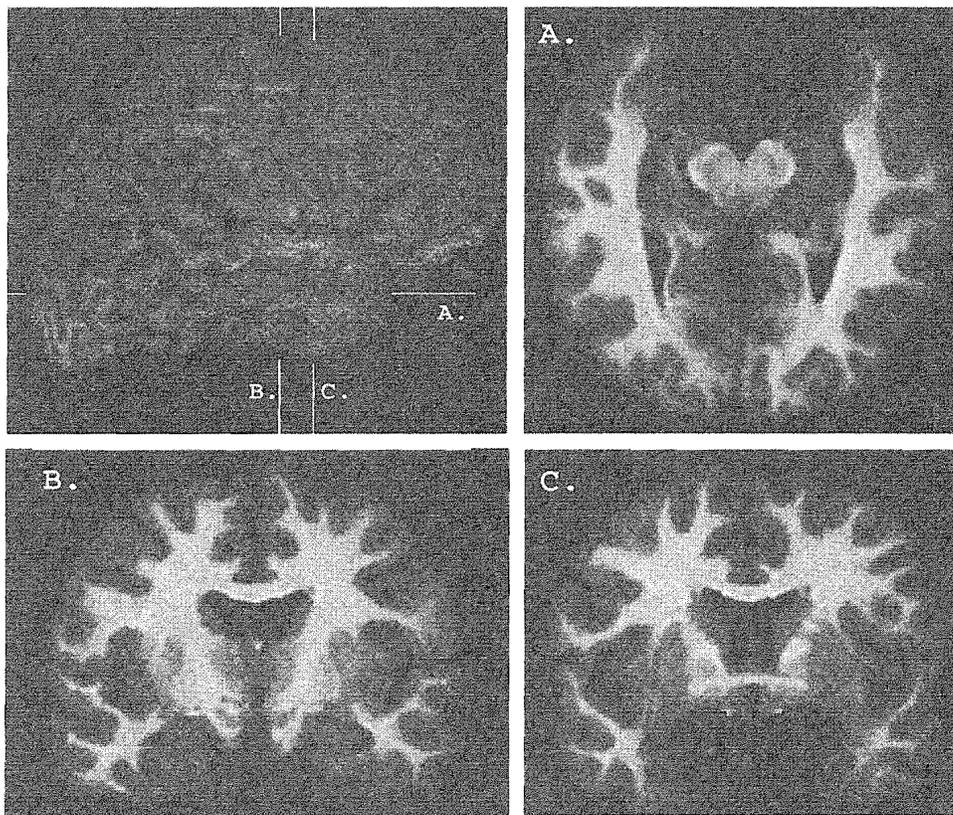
Neuroanatomy of S.M.046. Shown at top left is a three-dimensional reconstruction of S.M.’s brain from MR images, showing the planes of section of the other cuts. The symmetrical region of low signal in the anteromedial temporal lobe is due to
